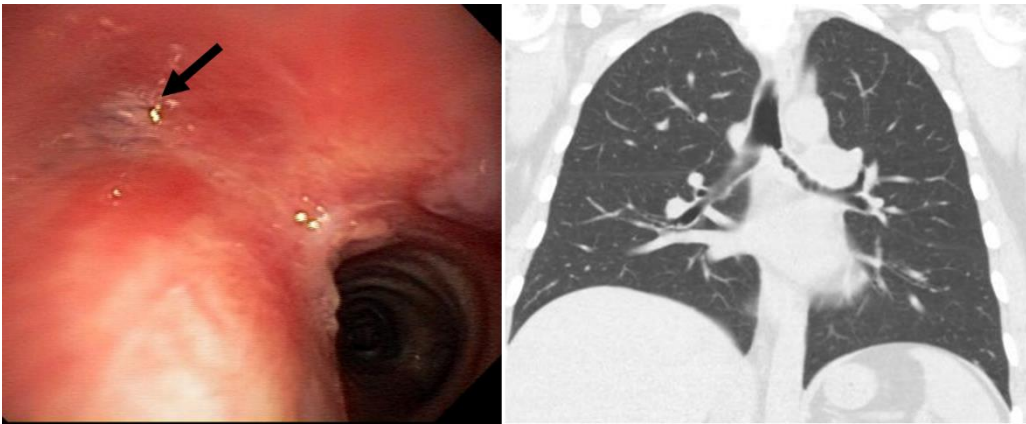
Left main bronchial stenosis, visible on bronchoscopy (left image), with beading appearance on axial CT scan (right image).
